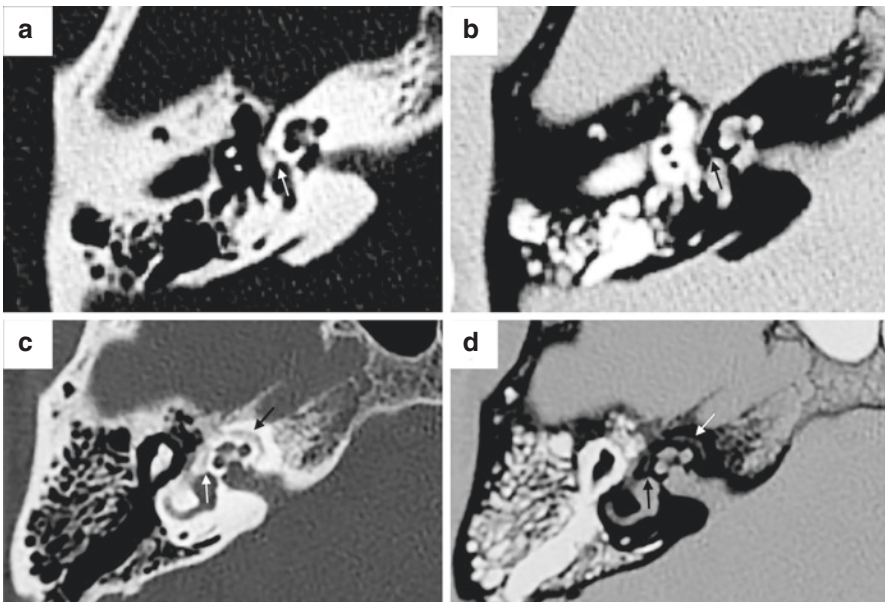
Fenestral Otosclerosis seen in regular and invert-function CT scan (a, b) and cochlear (retrofenestral) otosclerosis seen in c, d. (Reproduced with permission of *Annals of Otolaryngology, Rhinology & Laryngology* [8])
